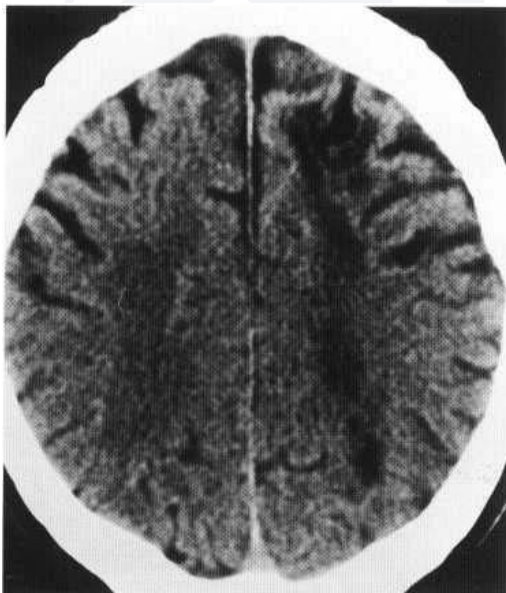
CT shows watershed infarct at junction of LMCA and ACA territory.
